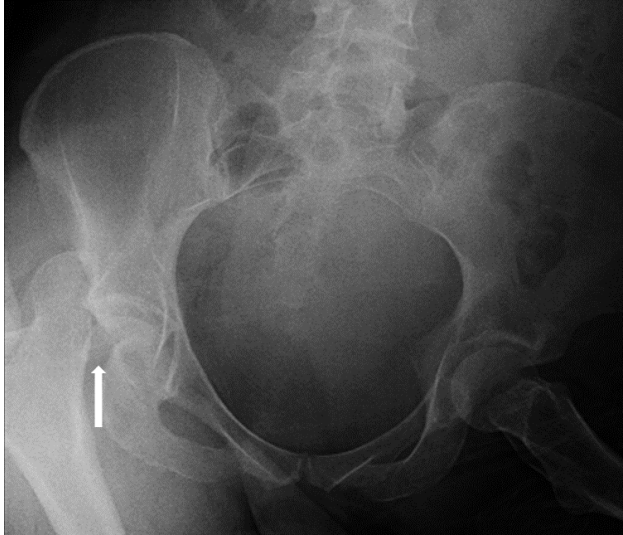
Pre-reduction radiograph demonstrating right sided posterior hip dislocation with inferior femoral head fragment (arrow) contained within the joint capsule
